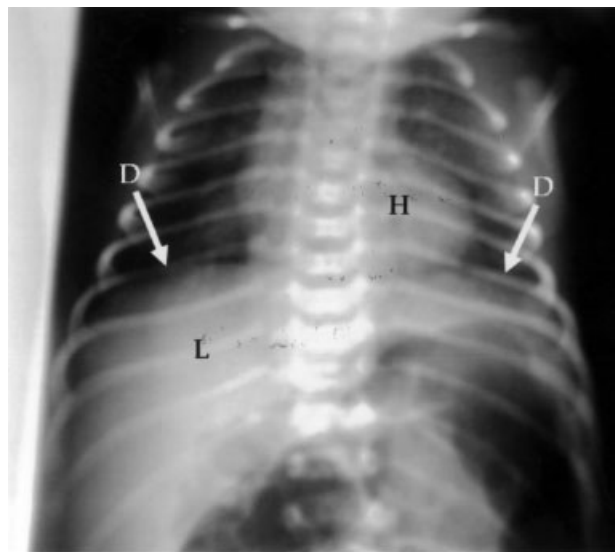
Postdelivery chest radiography revealing normal pulmonary status and diaphragmatic image (D), with no heart (H) deviation. L: liver
